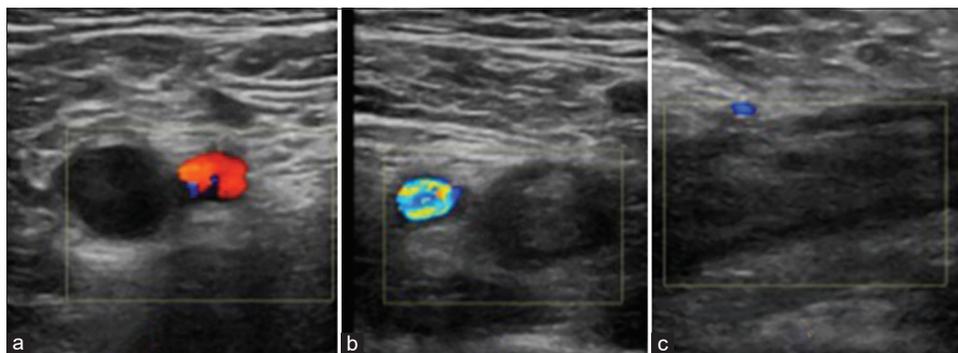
Color Doppler ultrasound of the right (a) and left (b and c) common femoral vein (CFV). A = Transverse view of the normal compressible right CFV with no filling defect. B = Abnormal left CFV with echogenic thrombus in the CFV which is non-compressible and no color flow. C = Longitudinal view of the echogenic thrombus occupying the CFV in keeping with a deep vein thrombosis.
